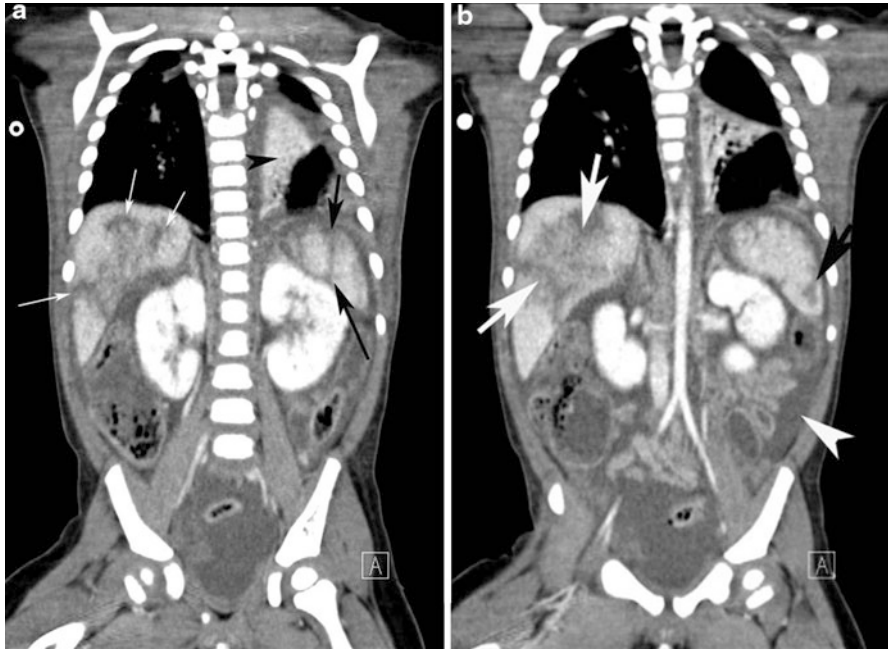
Coronal CT images of the chest, abdomen, and pelvis in a 19-month-old male with non accidental trauma showing hepatic (*white arrows*) and splenic lacerations (*black arrows*). Collapsed left lower lobe segments are noted (*black arrowhead* in figure a). High-density free fluid/hemoperitoneum is also seen in the left lumbar region (*white arrowhead* in figure b).
